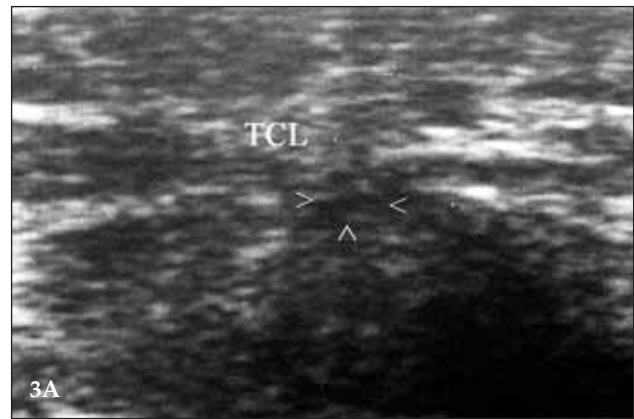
A. Ultrasonographic examination before sectioning of the ligament revealed the compression of the median nerve in the carpal tunnel (TCL: Transverse ligament, Arrows shows the median nerve). B. Intraoperative ultrasonographic examination shows the decompressed median nerve. (TCL: Transverse ligament, I: incision of the ligament, Arrows show the decompressed median nerve).
